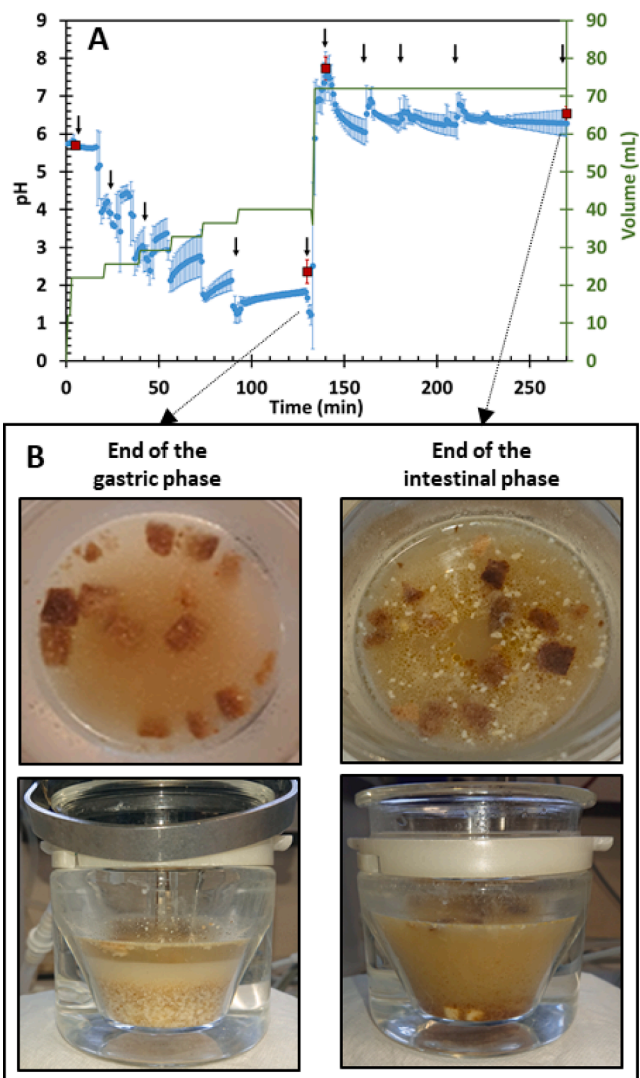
(A) Overview of the experimental conditions during the digestion experiments. Blue circles and red squares represent pH evolution during the biochemical and MRI experiments (left-hand y-axis), respectively. Values are mean \pm standard deviation for 3 replicates. The solid green line represents the time-course of the digesta volume during the MRI experiments (right-hand y-axis), and arrows indicate the times at which samples were collected from the supernatant during the biochemical experiments. (B) Visual appearance of the digesta at the end of the gastric and intestinal phases. (For interpretation of the references to colour in this figure legend, the reader is referred to the web version of this article.)
